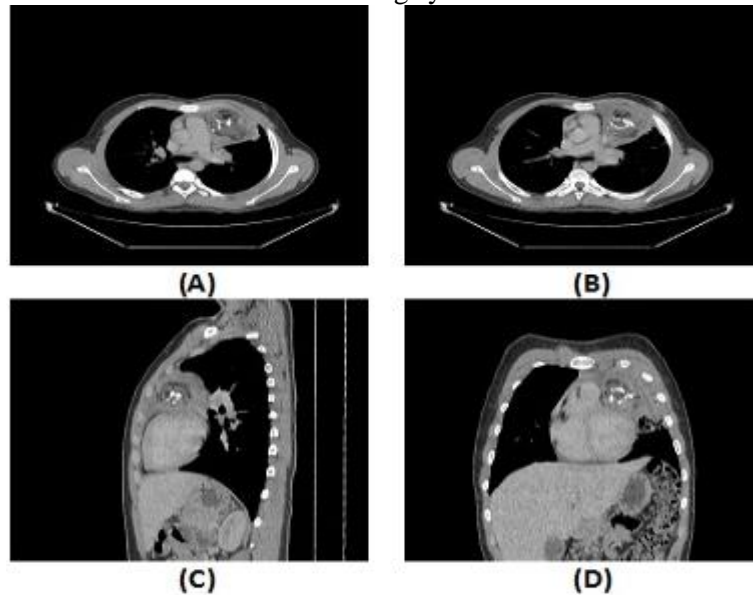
Mediastinal teratoma in a female patient aged 30 years old presenting with cough. (A, B) axial post contrast CT images showed well defined anterior mediastinal mass lesion with fat density and calcification inside measuring about 8.5 x 6.5 cm in maximal axial dimensions with adjacent left lower lung lobe pneumonitis. (C, D) coronal and sagittal reconstructed images.
